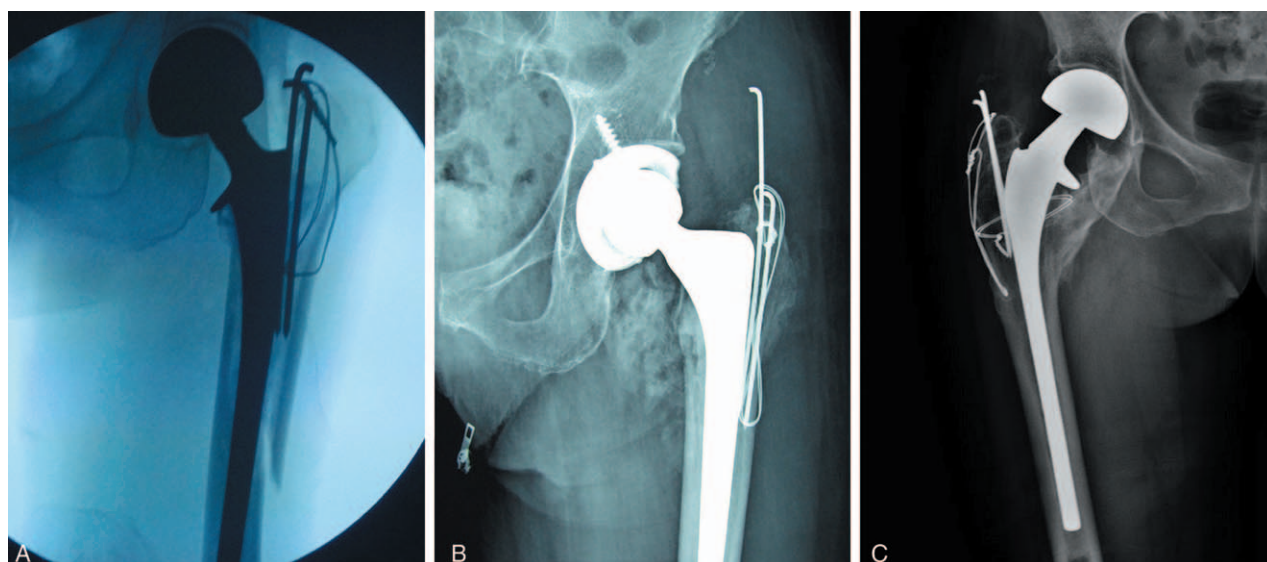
(A) Anteroposterior radiograph demonstrating a peri-prosthetic longitudinal fracture around a cemented stem intraoperatively; (B) anteroposterior radiograph demonstrating a K-wires retrograding; (C) anteroposterior radiograph demonstrating heterotopic ossification around the hip.
